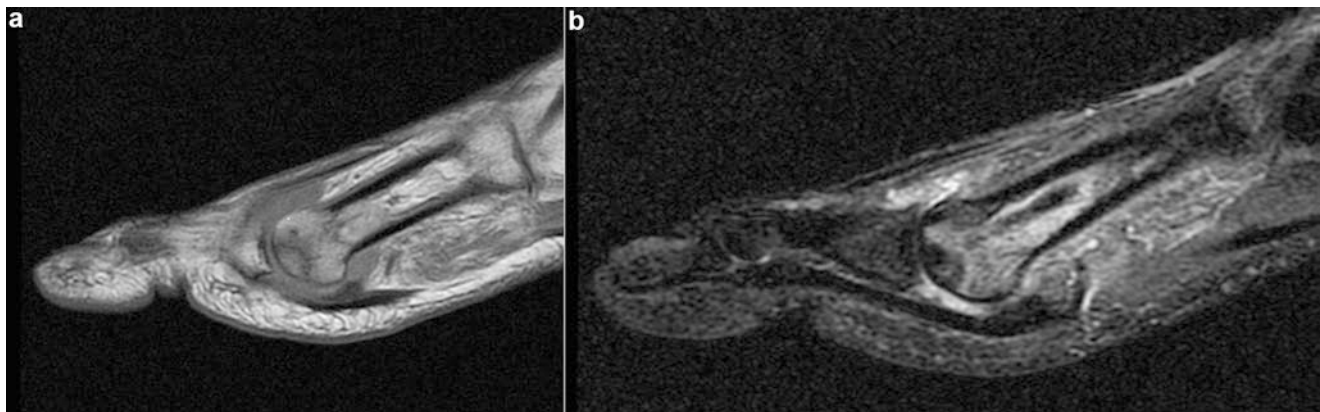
(a, b) MRI of AVN of the first metatarsal showing a decrease signal intensity on T1 image and a corresponding increased signal intensity on double on T2-weighted image with a double-line sign
